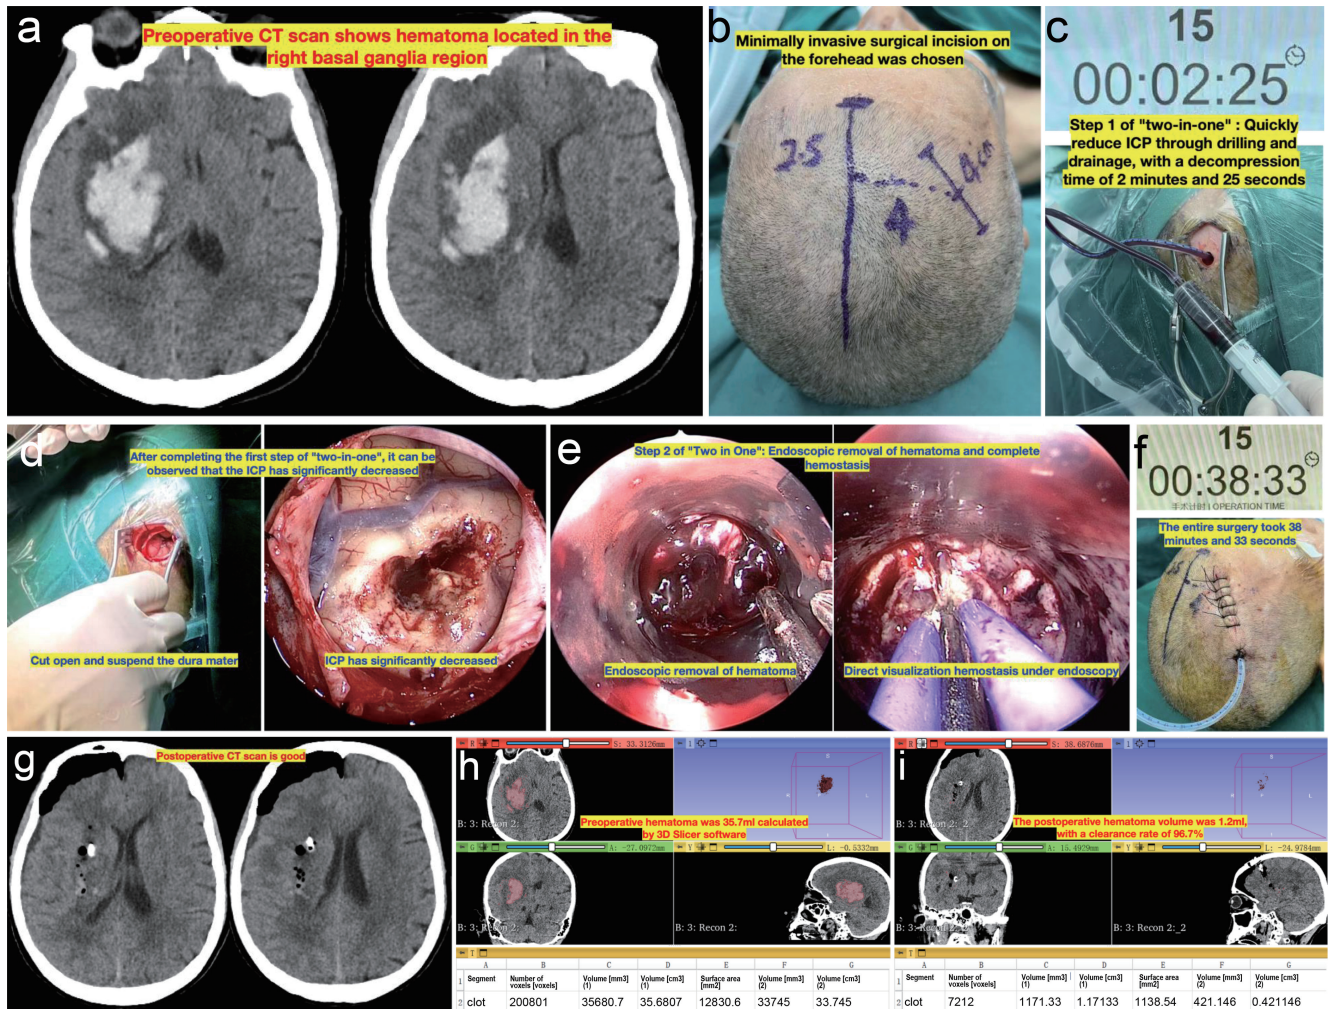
The two-in-one surgical strategy for basal ganglia hemorrhage. (a) Preoperative non-contrast axial CT scan showing a hematoma located in the right basal ganglia, and the midline structure was shifted. (b) A 4-cm linear scalp incision was performed. (c) A burr hole was made, a soft catheter was inserted into the hematoma cavity, and approximately one-third of the hematoma was aspirated through the catheter using a syringe; the decompression time was 2 min 25 s (defined as the interval from skin incision to the first observed reduction of intracranial pressure on the ICP monitor). (d) After completing the first step of “two-in-one”, it can be observed that the ICP has significantly decreased. (e) The residual hematoma was evacuated, and complete hemostasis was achieved under direct neuroendoscopic view. (f) The entire surgery took 38 min and 33 s. (g) Postoperative CT scan showing that the hematoma was removed satisfactorily. (h) Preoperative hematoma volume was 35.7 mL, calculated by 3D Slicer software. (i) The postoperative hematoma volume was 1.2 mL, with a clearance rate of 96.7%. CT, computed tomography; ICP, intracranial pressure.
